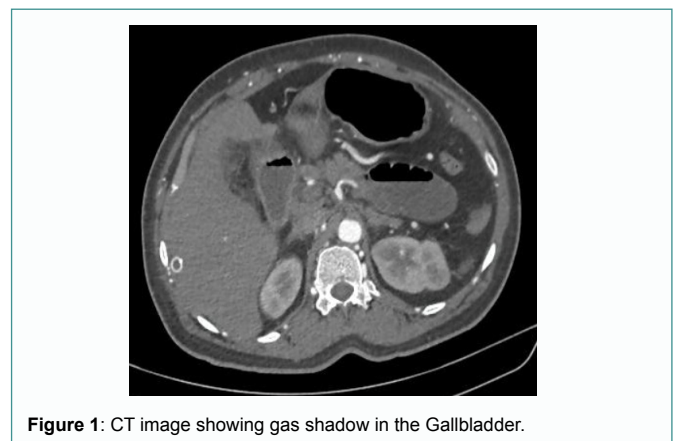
CT image showing gas shadow in the Gallbladder.
